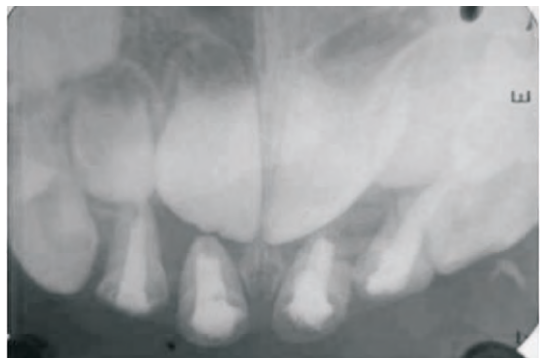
Post-operative radiograph with obturated 51, 52, 61, and 62.
